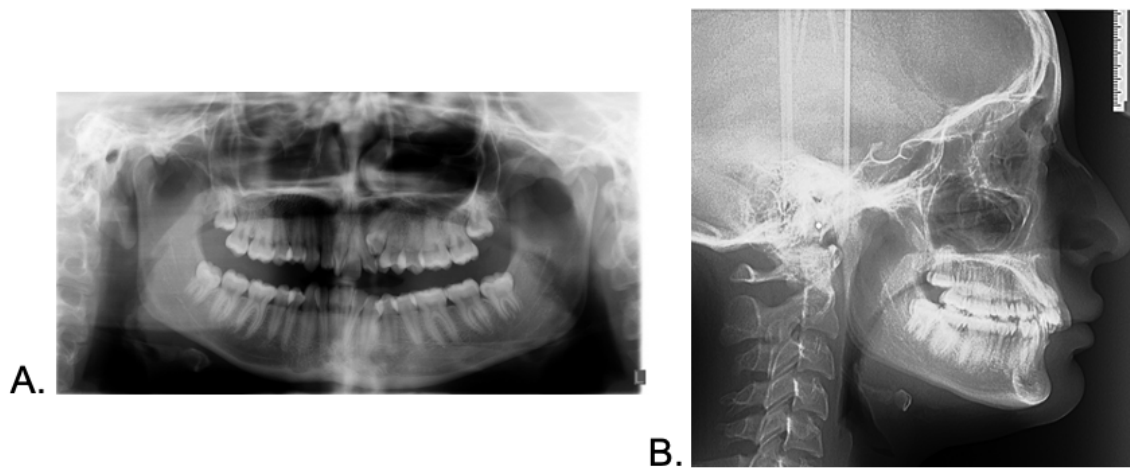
Initial radiographic records. A. Panoramic radiograph. B. Lateral headfilm.
